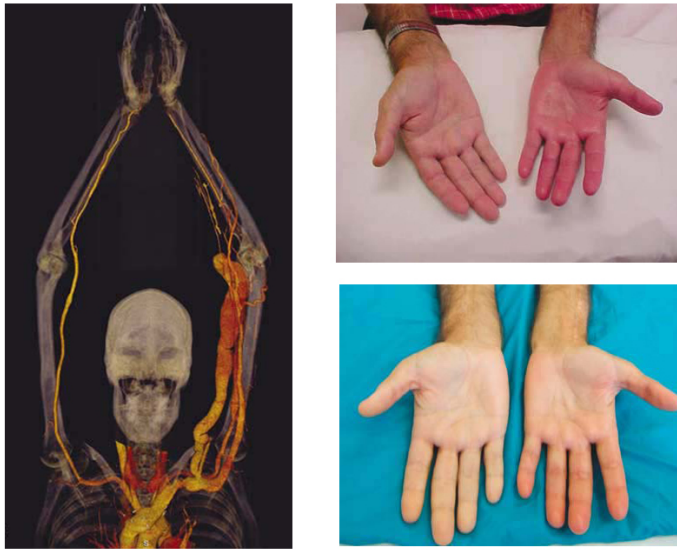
Left: Computed Tomography (CT) angiogram 3-D reconstructions revealing grossly dilated AVF, minimal arterial supply to the left hand, and venous dilation along the left brachial plexus; Top-right: Left hand ischemia; Bottom-right: Return of muscle mass, 3 months after ligation of the high-flow fistula [43].
